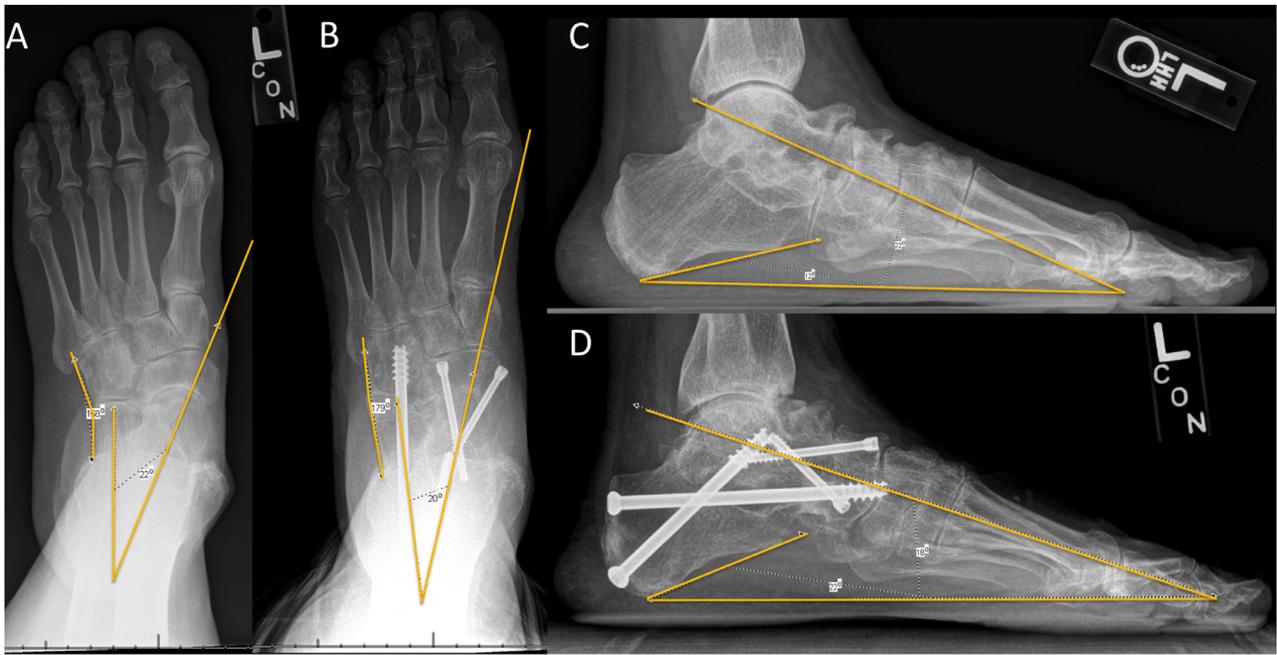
A 63-year-old female with stage 3C posterior tibial tendon dysfunction corrected with subtalar and talonavicular joint arthrodesis with adjunctive calcaneocuboid joint distraction arthrodesis. Anteroposterior preoperative (A) and postoperative (B) radiographs show correction in the transverse plane. Lateral preoperative (C) and postoperative (D) radiographs show correction in the sagittal plane.
